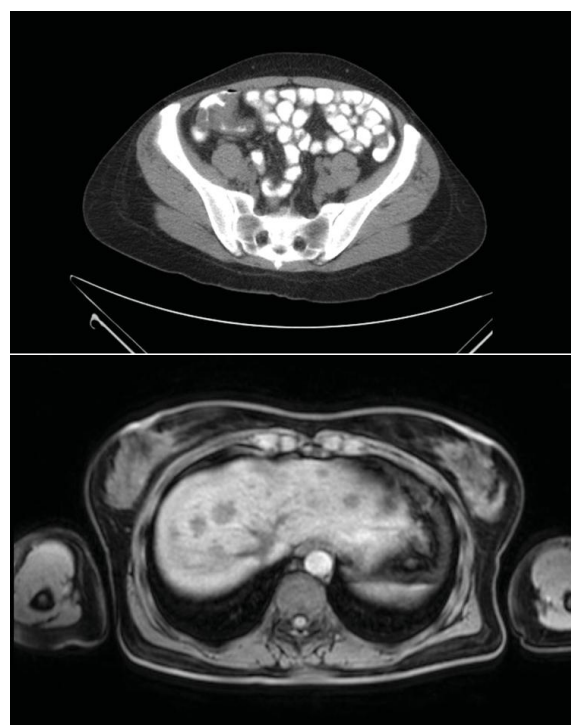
Contrast-enhanced CT abdomen/pelvis showing a solid mass at the ileocecal valve, extending into the terminal ileum b) Abdominal MRI revealing multiple hepatic metastatic lesions.
